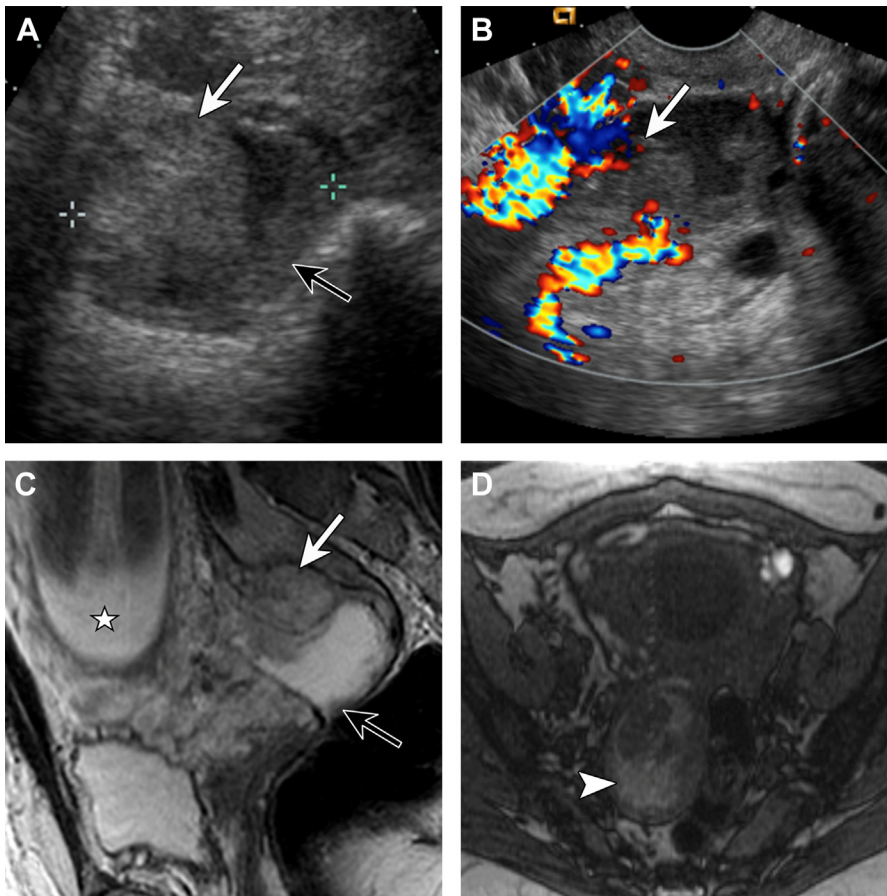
Decidualized endometrioma mimicking ovarian malignancy. A 34-year-old woman found to have an incidental adnexal mass during routine obstetric ultrasound, proven to be a decidualized endometrioma after surgical resection at the time of cesarean section. Gray scale ultrasound (US) image (A) demonstrates a unilocular mass (calipers) with solid components (black and white arrows). As shown here, decidualization can be nonuniform presenting as solid nodules (white arrow) or solid tissue (black arrow) along the wall of the endometrioma. Color Doppler US (B) shows the mass to be markedly hypervascular. Note the smooth and rounded appearance of the solid component that has been described to be typical of decidualized endometriomas (white arrow). Sagittal T2-weighted MR image (C) shows the same cystic mass with nonuniform solid components (white and black arrows). Note the gestation in the uterus (star). Axial T1-weighted image (D) shows intrinsic T1 hyperintensity of the fluid contents (white arrowhead), which is suggestive of hemorrhagic contents, that can be seen in endometriomas. However, imaging distinction from malignancy remains challenging.
